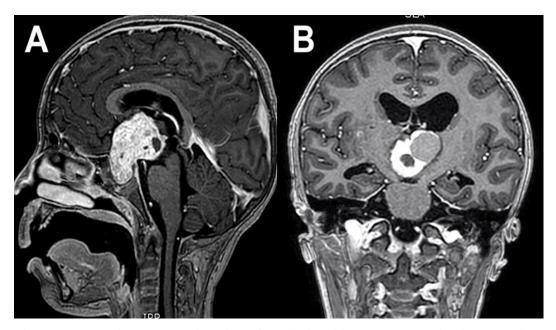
Magnetic resonance imaging of the brain with contrast, showing in the sagittal (A) and coronal (B) sections a tumor with solid-cystic features in the suprasellar sellar region, which is indicative of craniopharyngioma.
